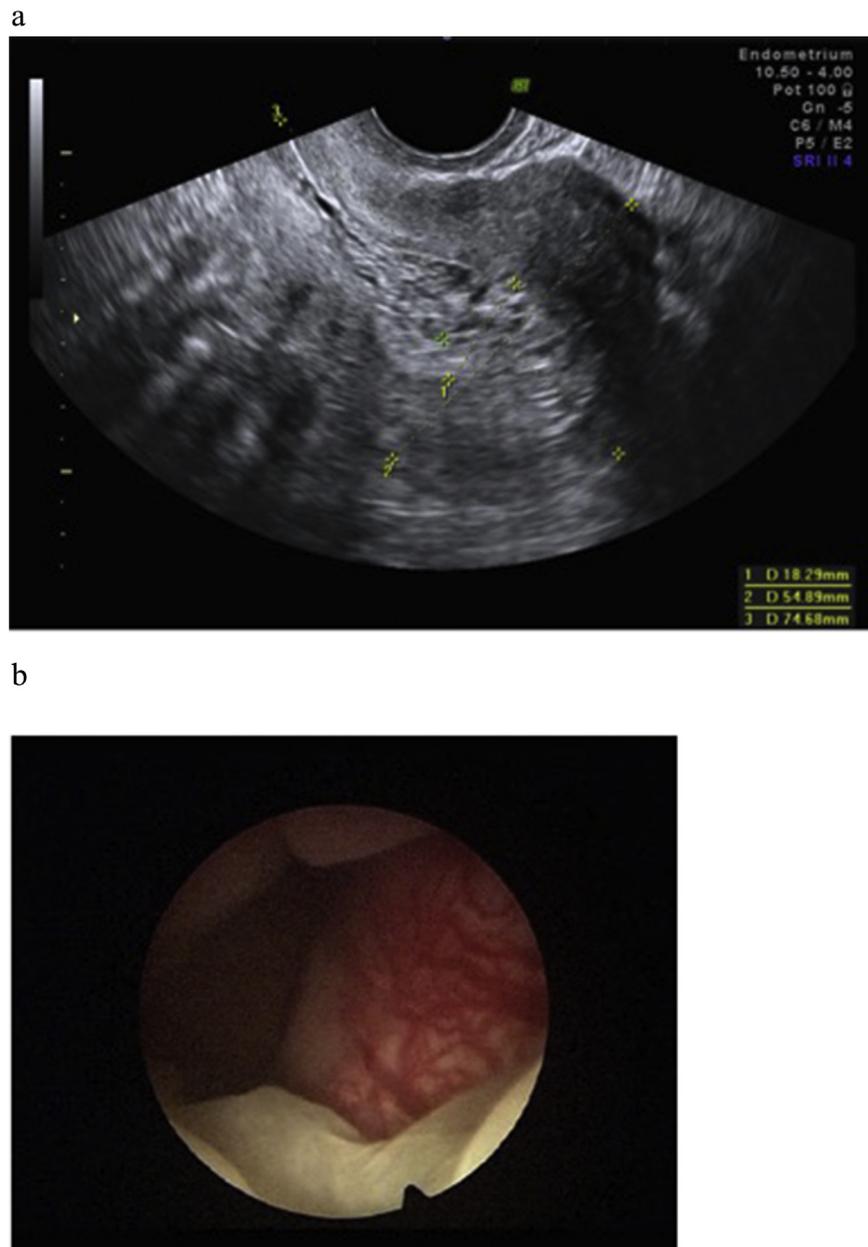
Images of sonographic and hysteroscopic patterns suggestive of PRM effect in the endometrium. A. Transvaginal ultrasound findings suggestive of PRM effect. Endometrial thickness of 18.2 mm described as a pseudocystic non-homogeneous pattern according to the IETA criteria. [14] B. Hysteroscopy shows areas with cystic atrophy, floating areas, and a “chicken-wire” vessel pattern according to the hysteroscopic pattern suggestive of PRM effect described by Bettochi et al. [9].
